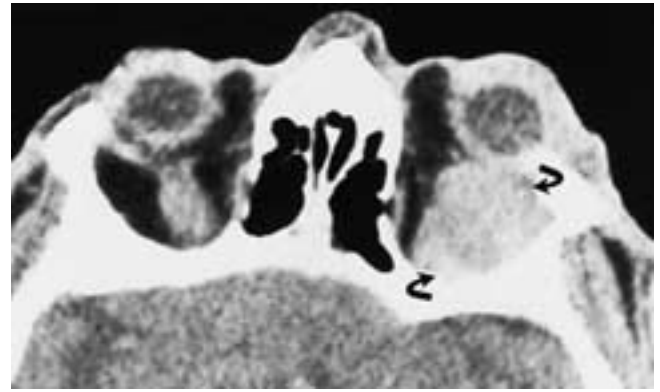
Lymphoma. Axial postcontrast CT scan shows a large mass in the superior temporal quadrant extending posteriorly to the orbital apex (arrows); the lacrimal gland is totally involved. Note the postsurgical changes in the lateral wall of the left orbit.
